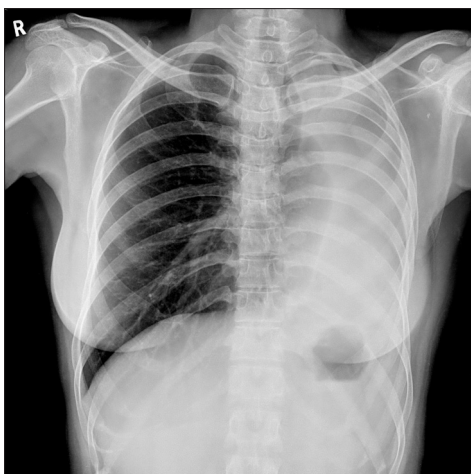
Chest radiograph showing collapse of the left lung
